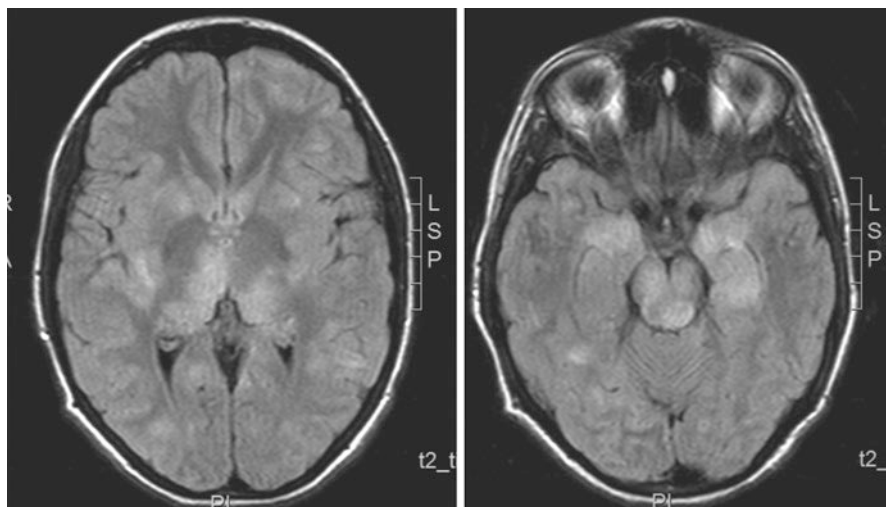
Brain MRI (T2-weighted sequences) from a 16-year-old girl with acute demyelinating encephalomyelitis following a nonspecific upper respiratory infection. There was an extensive involvement of the gray and white matter both supra- and infratentorial. She presented with fever, seizures and decreased level of consciousness, and CSF lymphocytic pleocytosis. The clinical picture and MRI abnormalities normalized over several months after initial intensive steroid therapy.
